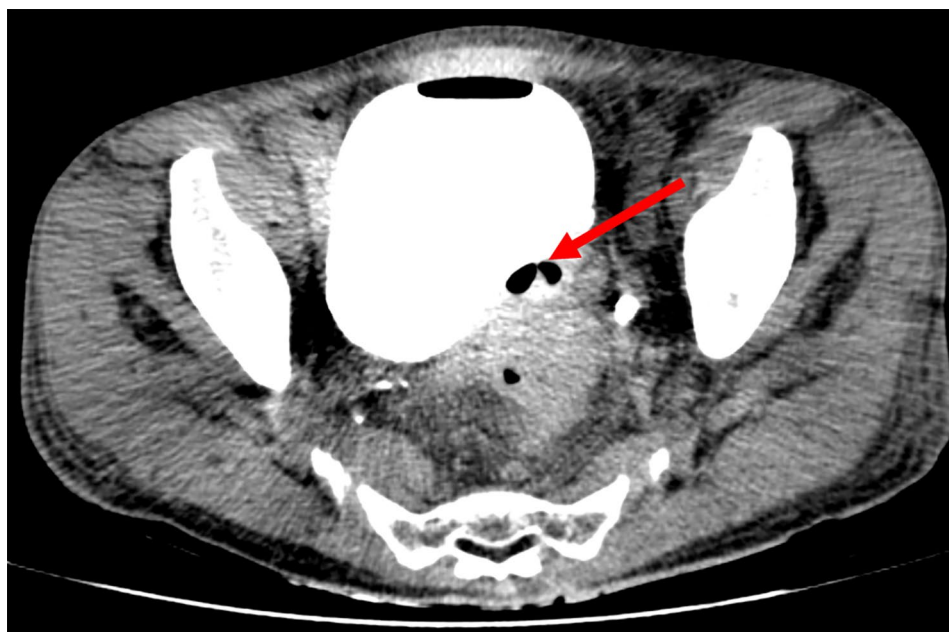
Contrast-enhanced pelvic CT (axial view). Irregular thickening of the sigmoid colon wall is observed. Small gas bubbles are visible between the prostate and rectum, suggesting the possibility of a sigmoid-vesical (colovesical) fistula formation
